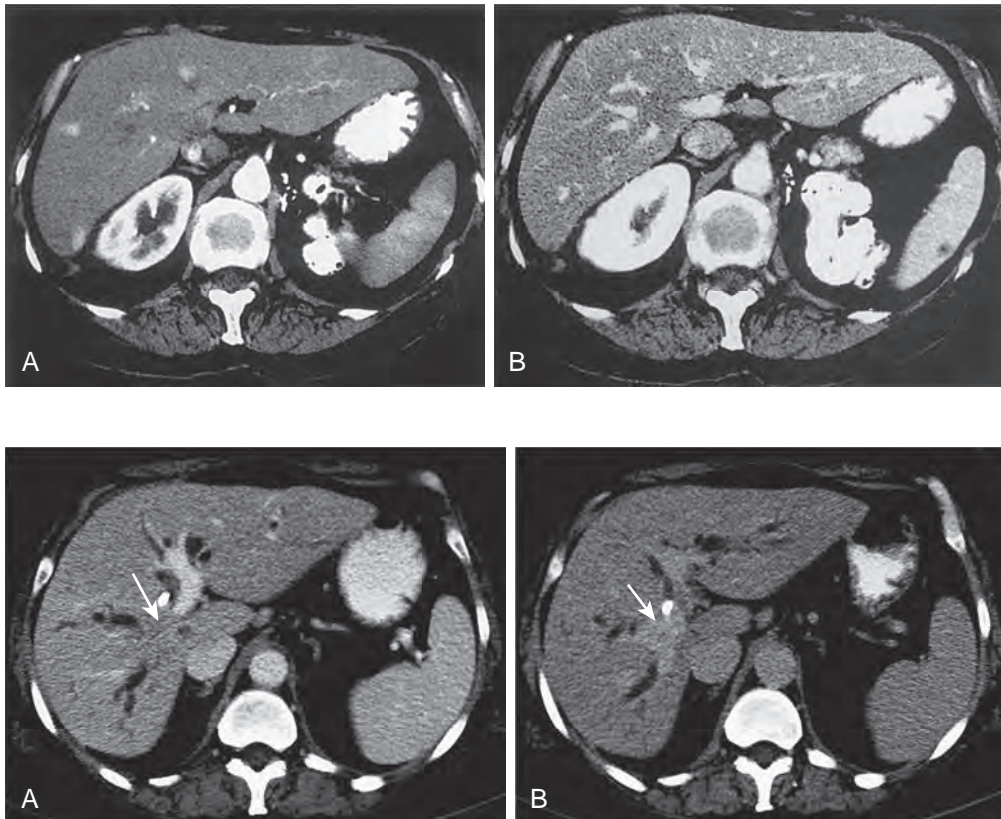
Hypervascular metastases: biphasic CT demonstrating carcinoid metastases only on arterial phase images. Arterial phase CT image (A) demonstrates multiple brightly enhancing metastases that are invisible on portal venous phase scan (B). Images are displayed at narrow (liver) windows.
